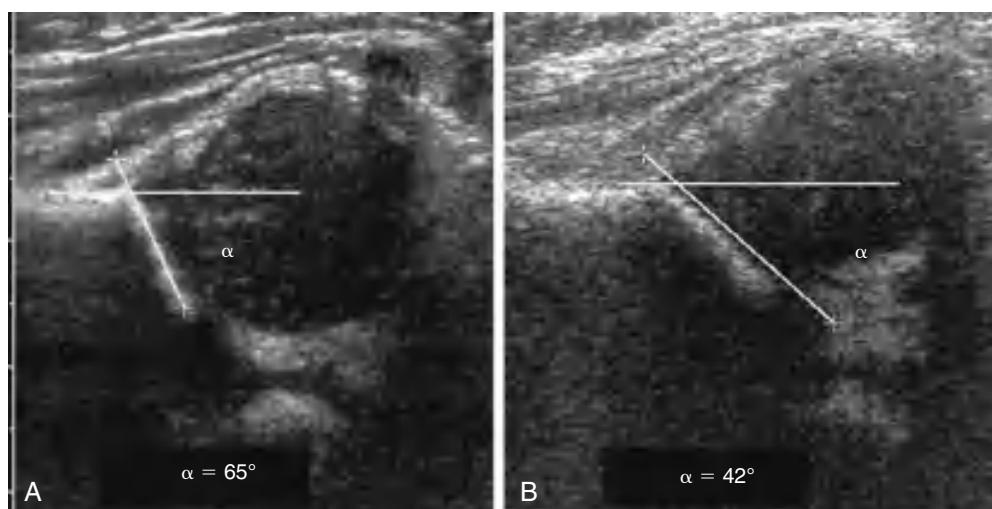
A, Normal ultrasonographic image of the hip in an infant. The α angle is >60 degrees. Note that a line drawn tangential to the ilium falls lateral to the center of the femoral head. B, In this child with developmental dysplasia of the hip, the left hip demonstrates an α angle of 42 degrees, and a line drawn tangential to the ilium shows that <50% of the femoral head is contained within the acetabulum.
